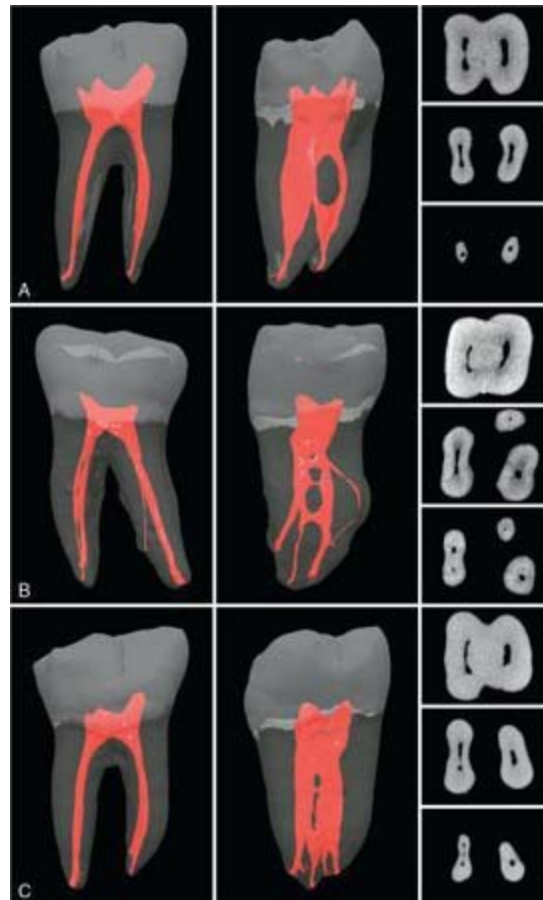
μ CT scans of mandibular first molars. A, Common anatomic presentation. B, First molar with three main canals and a deviant fourth canal/fourth root. C, First molar with wide connections or anastomoses between the mesial canals, demonstrating multiple canal exits. All teeth are shown from both a buccal (vestibular) and a proximal perspective, along with the cross-sectional anatomy at the coronal, middle, and apical levels. (See Video 7.17 online at the Expert Consult site for rotational views of these teeth.)
